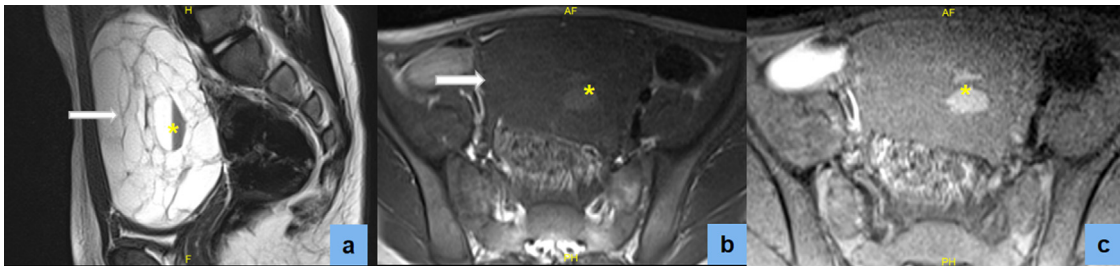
Pelvic magnetic resonance imaging (MRI) without contrast enhancement revealed a large, multilobulated cystic mass of the left ovary, featuring multiple, irregular septa forming many compartments (sponge-like or honeycomb-like shape), which contained homogeneous fluid-filled cysts (arrows) with hyper signal intensity (SI) on T2-weighted (T2W) imaging (a). A small number of cysts were observed with blood-fluid levels, low SI on T2W (a), high SI on T1-weighted (T1W) images (b) and T1-weighted fat saturation (T1WFS, c) images, indicating hemorrhaging within the cysts (asterisks).
